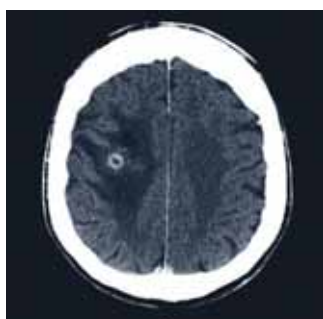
CT brain post contrast one month post debulking of brain abscess. Note decrease in size of ring enhancing lesion.
